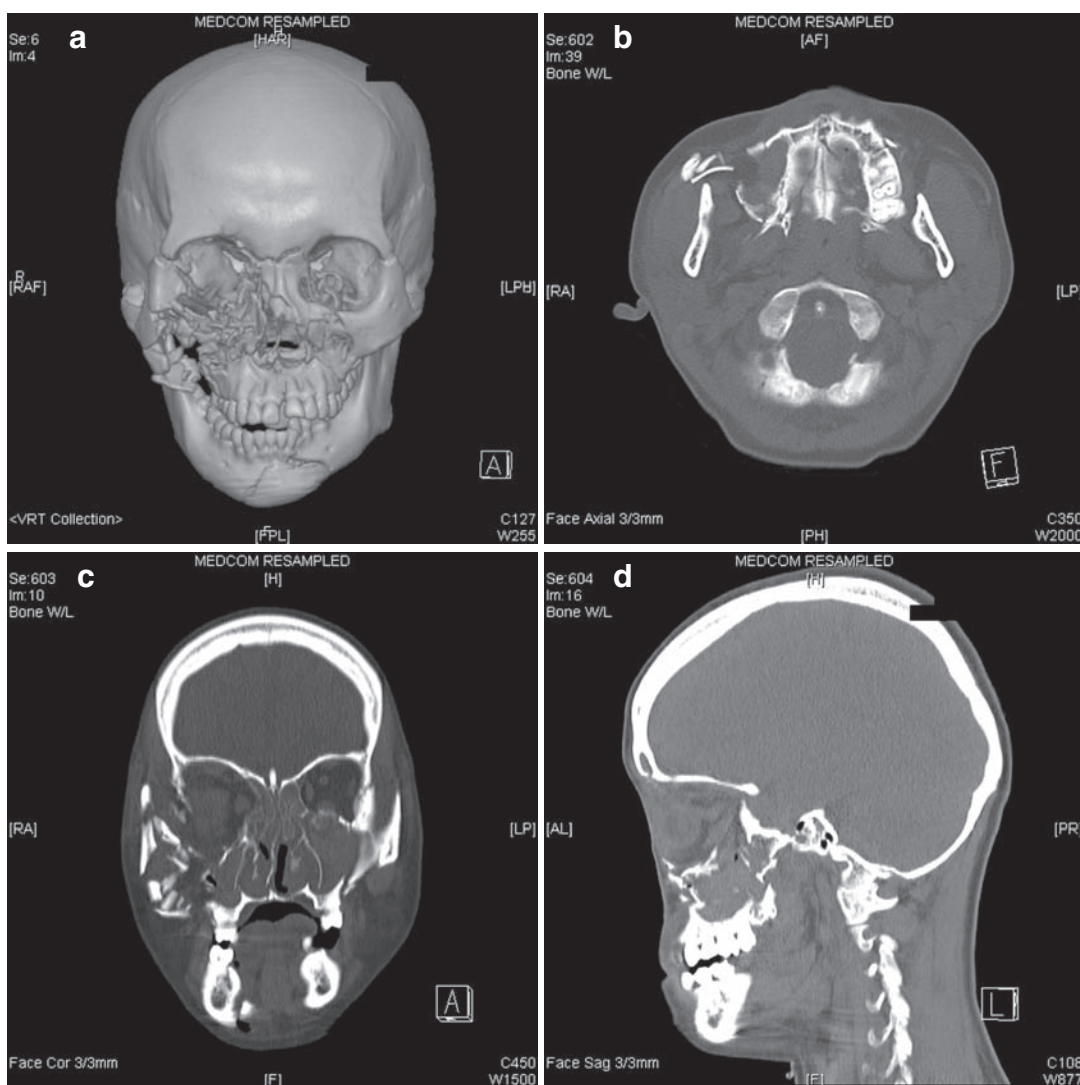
CT scan of a complex orbit, zygoma, maxilla, palate, mandible, and naso-orbit-ethmoidal fractures. (a) 3D CT scan. (b) Axial view of CT scan. (c) Coronal view of CT scan. (d) Sagittal view of CT scan.
